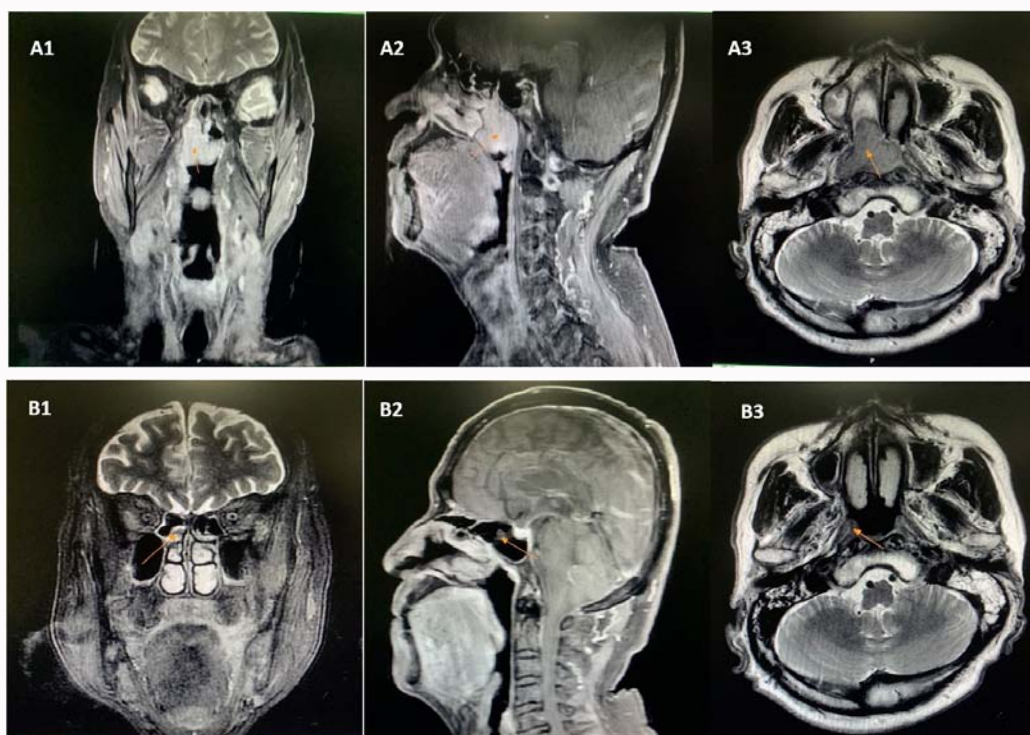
Dynamic changes in MRI of the nasopharynx during treatment.
